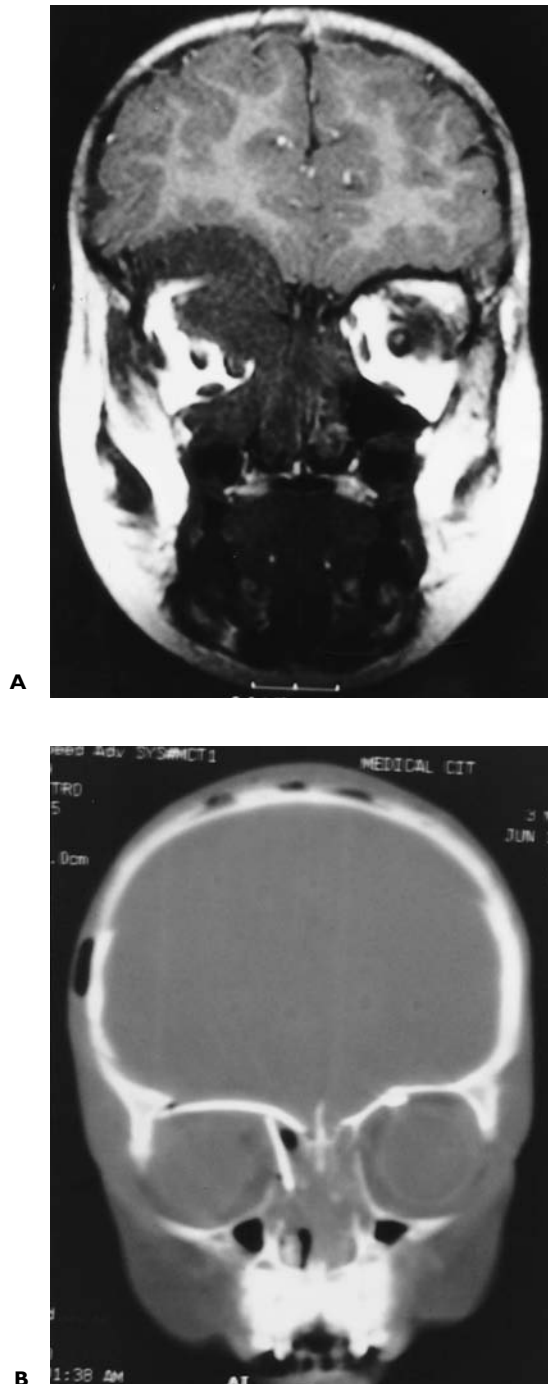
Tumor of right orbit and postoperative bony reconstruction of the orbit. A: Coronal MRI scan without gadolinium showing low-grade myxosarcoma invading the intracranial space and right orbit in a 3-year-old boy. B: Postoperative coronal CT scan showing the repositioning of the cribriform plate (this was anterior to the tumor and olfaction was preserved). Also shown is the split bone reconstruction of the right orbital roof and medial orbital wall.
